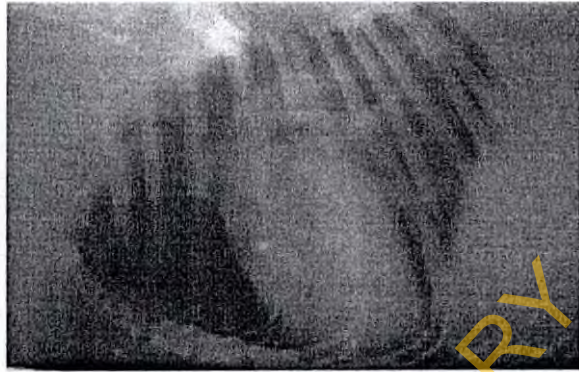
Lateral radiograph of the chest. Note heart and vessel size are within normal limit
